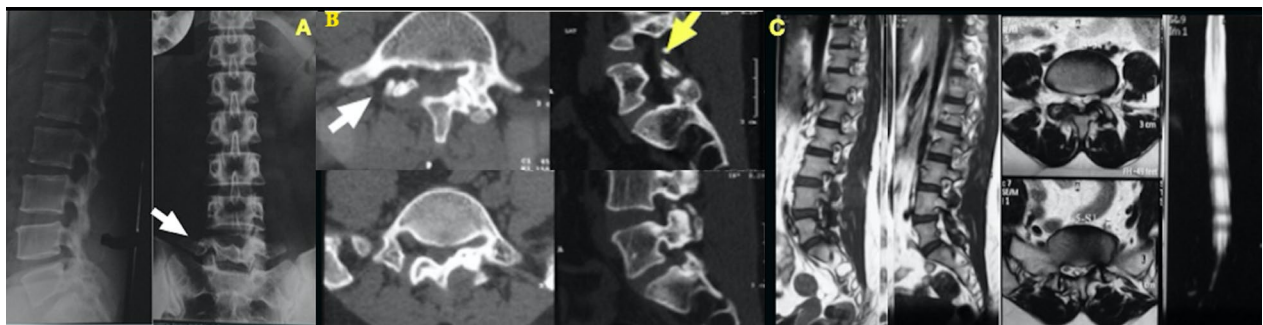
a Plain radiographs of case 3 depicting hypoplasia of facet joints on right side and facet arthropathy on the left side. b Corresponding CT scan images showing corroborative findings and hypoplastic L5 pedicle on right side. c T2 Sagittal and axial MRI images demonstrating contained disc herniation on left side at L4/5 and L5/S1 facet arthropathy on right side and hypoplastic L5 pedicle
